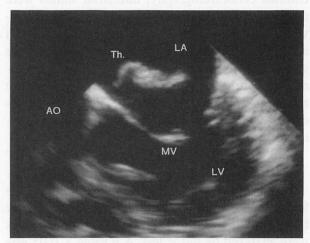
Transesophageal echocardiogram of a patient with reembolization (case 11)
